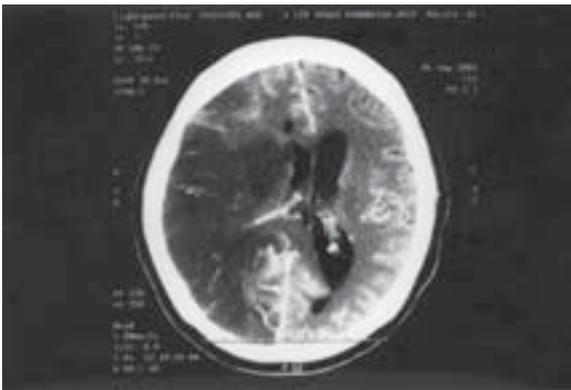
Post-contrast-enhanced CT, done 6 weeks after admission, showing cerebral infarct in the right middle cerebral artery distribution with mass effect and shift of midline with associated hydrocephalus. An area of hypodensity seen at the right frontal horn is suggestive of an old infarct.
